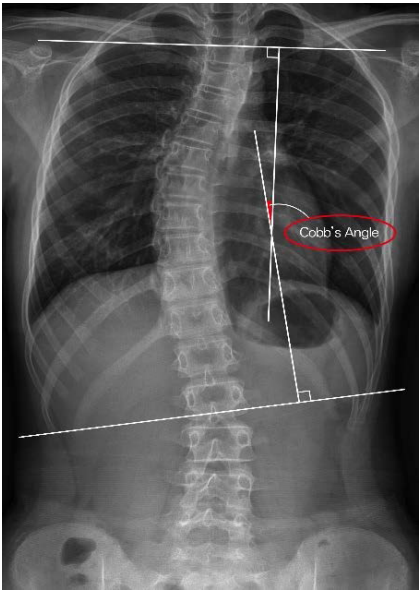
Cobb's angle evaluation using X-ray imaging.
